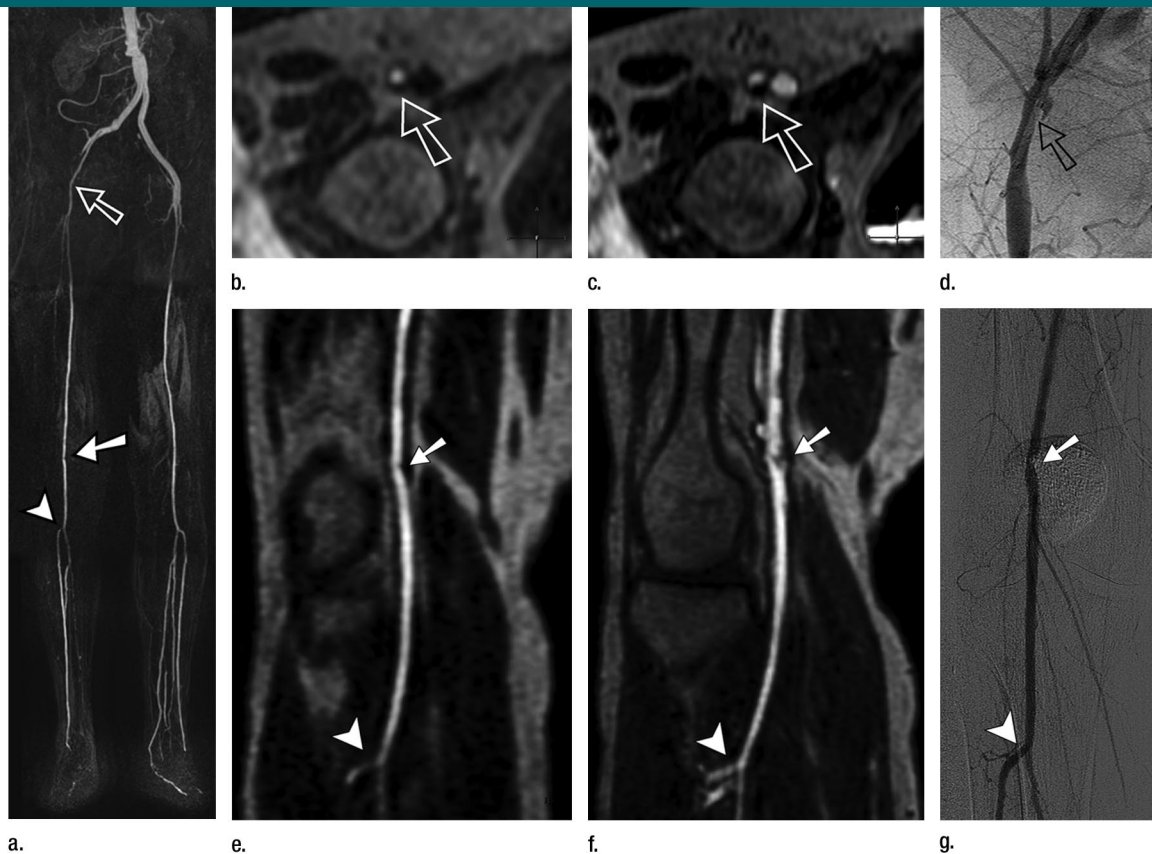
MR angiographic and DSA images of stenosis ($>50\%$) of the right common femoral artery (open arrow), high-grade stenosis of the right popliteal artery (solid arrow), and absence of stenosis at the origin of the right tibial artery (arrowhead) in a 56-year-old woman. This patient had a right aortoiliac and left aortofemoral bypass graft from previous surgery. (a) Fused maximum intensity projection of moving-table-subtracted contrast-enhanced T1-weighted gradient-echo images. (b) Cross-sectional multiplanar reformation of contrast-enhanced T1-weighted gradient-echo images (2.7/0.89) during the arterial first pass. (c) Cross-sectional multiplanar reformation of high-spatial-resolution contrast-enhanced T1-weighted gradient-echo images (4.8/1.42) during the steady state. (d) Anterior view of selective DSA of right common femoral artery. (e) Curved multiplanar reformation of contrast-enhanced T1-weighted gradient-echo images (2.8/0.94) during the arterial first pass. (f) Curved multiplanar reformation of high-spatial-resolution contrast-enhanced T1-weighted gradient-echo images (4.9/1.44) during the steady state. (g) Anterior view of selective DSA of right popliteal artery and proximal anterior tibial artery. Stenosis grade of right common femoral artery was judged as less than 50% on first-pass MR angiograms, but as 50% or higher on steady-state MR angiograms and DSA images (open arrow). Stenosis grade of right popliteal artery was judged as less than 50% on first-pass MR angiograms, but as 50% or higher on steady-state MR angiograms and DSA images (solid arrow). Note the better visualization of proximal right anterior tibial artery on steady-state MR angiograms than on DSA images (arrowhead). Stenosis grading of the latter segment was judged as 50% or higher on first-pass MR angiograms and less than 50% on steady-state MR angiograms and DSA images.
